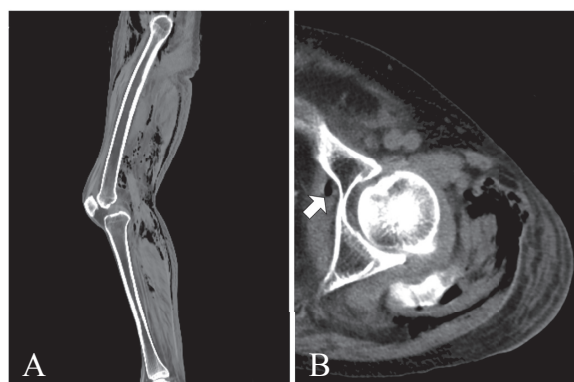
Sagittal view and axial view of extremities computed tomography (CT) without contrast. (A) It displayed extensive subcutaneous emphysema of left lower extremity mimic gas-forming myonecrosis (GFM). (B) It showed air existed in the pelvic cavity (arrow) provided a clue that the gas of the left lower extremities may originate from pelvic cavity.
